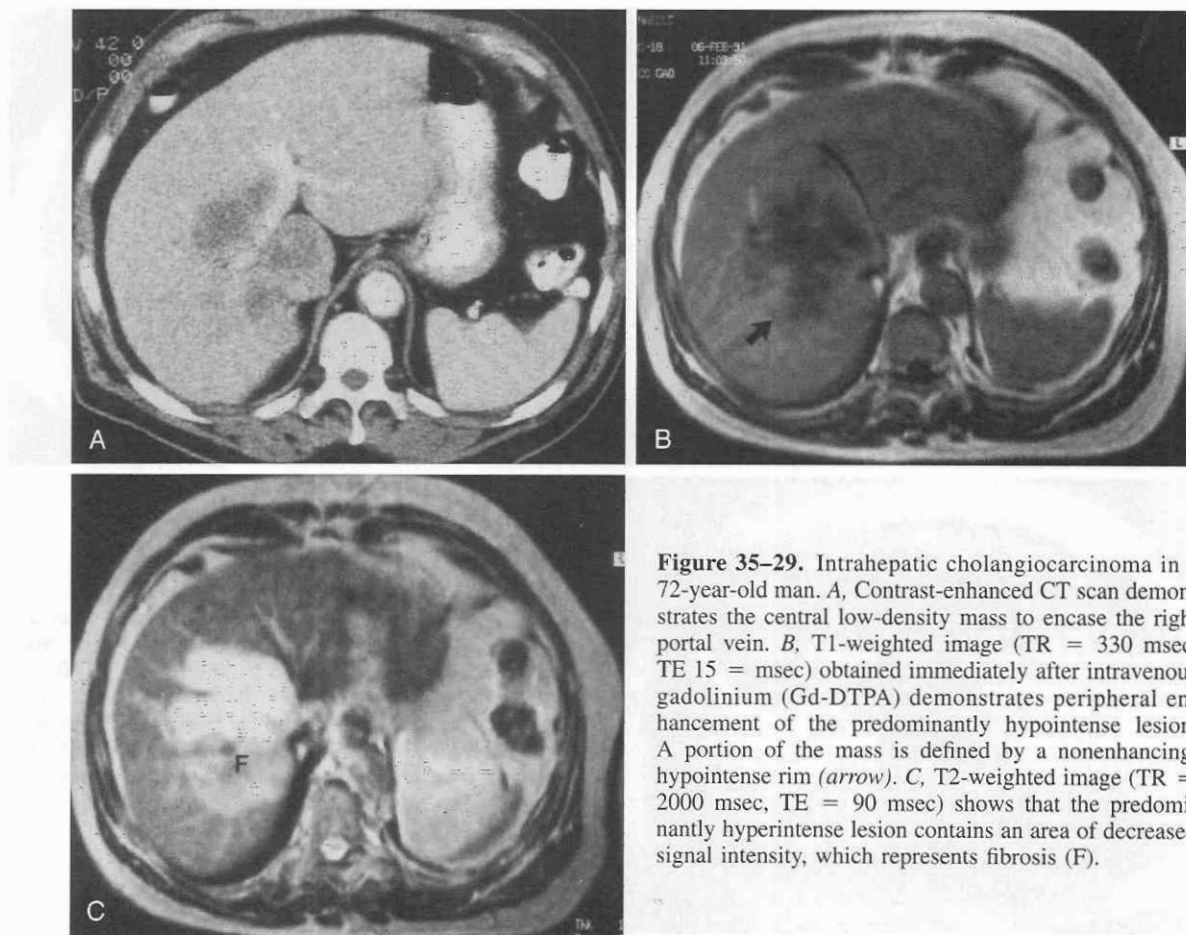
Intrahepatic cholangiocarcinoma in a 72-year-old man. A, Contrast-enhanced CT scan demonstrates the central low-density mass to encase the right portal vein. B, T1-weighted image (TR = 330 msec, TE 15 = msec) obtained immediately after intravenous gadolinium (Gd-DTPA) demonstrates peripheral enhancement of the predominantly hypointense lesion. A portion of the mass is defined by a nonenhancing, hypointense rim (arrow). C, T2-weighted image (TR = 2000 msec, TE = 90 msec) shows that the predominantly hyperintense lesion contains an area of decreased signal intensity, which represents fibrosis (F).
